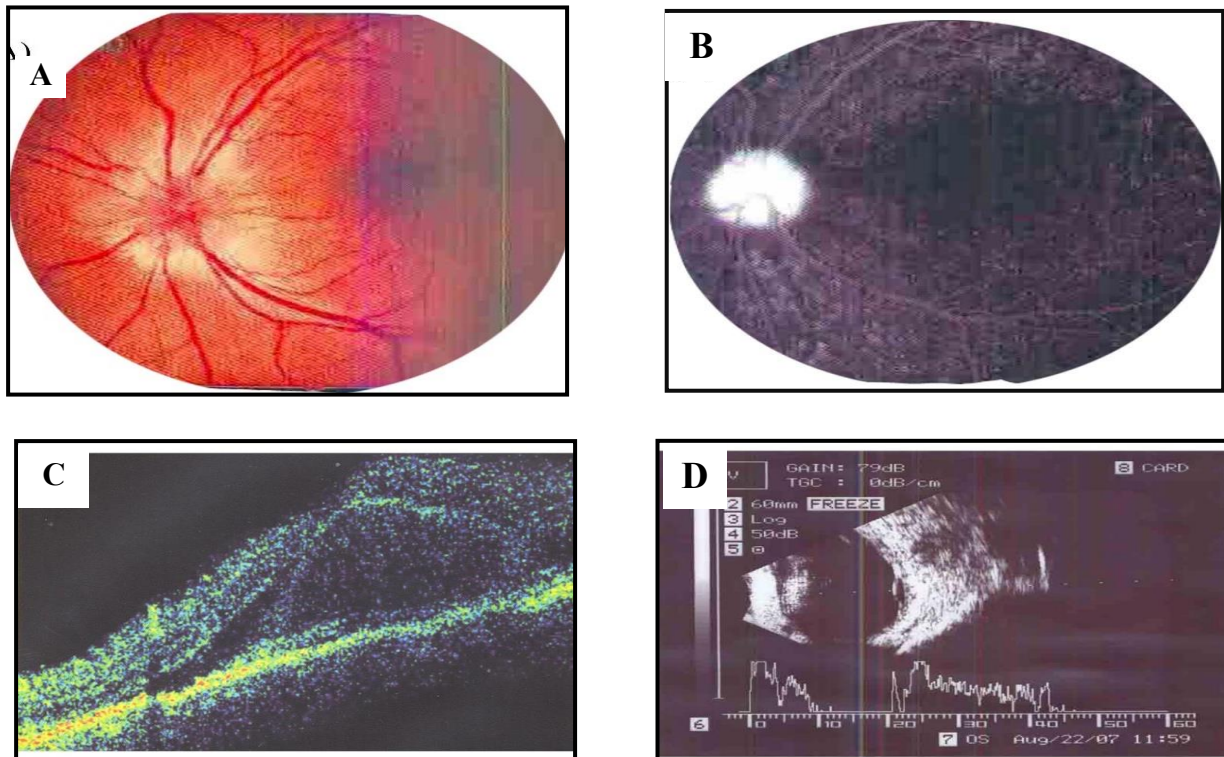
Initial examination of the left eye in case two (A) Color fundus images, (B) Fluorescence angiography, (C) O.C.T, and (D) ultrasonography
